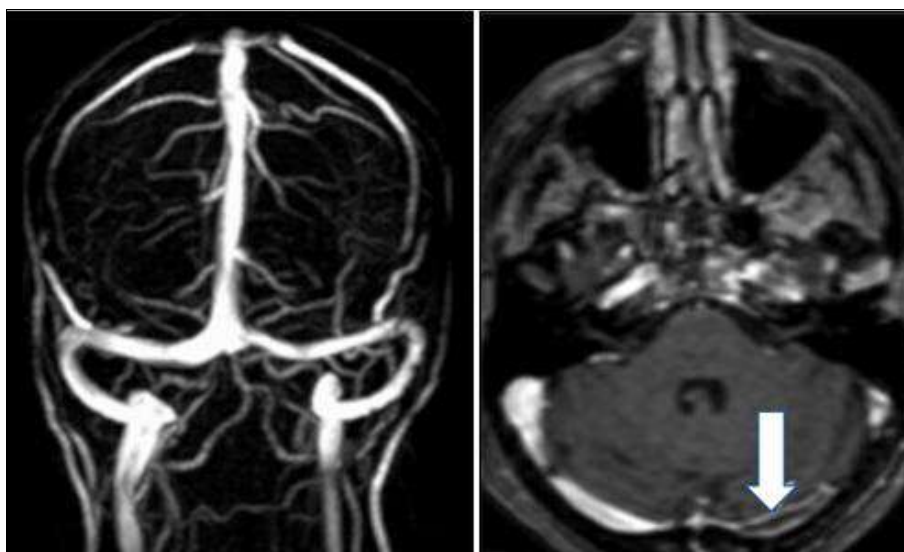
Cerebral venous thrombosis involving left transverse and sigmoid sinuses with acute haemorrhagic infarct. (a) FLAIR showed hyper intensities noted in left temporo parieto-occipital region, left capsule-ganglionic region.(b) SWI showed blooming (c) DWI showed areas of restricted diffusion and (d) ADC showed corresponding signal drop.(e) TOF image showed non visualisation of transverse and sigmoid sinuses (f) Post contrast showed filling defect in left transverse and sigmoid sinuses.
